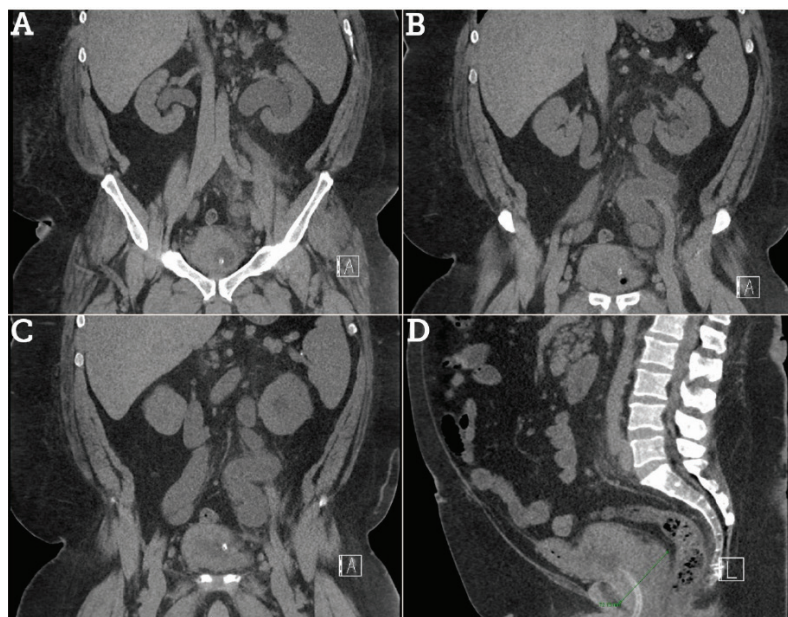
Coronal (A, B and C) and sagittal (D) computed tomography images demonstrating severe bilateral hydronephrosis and prostatomegaly
